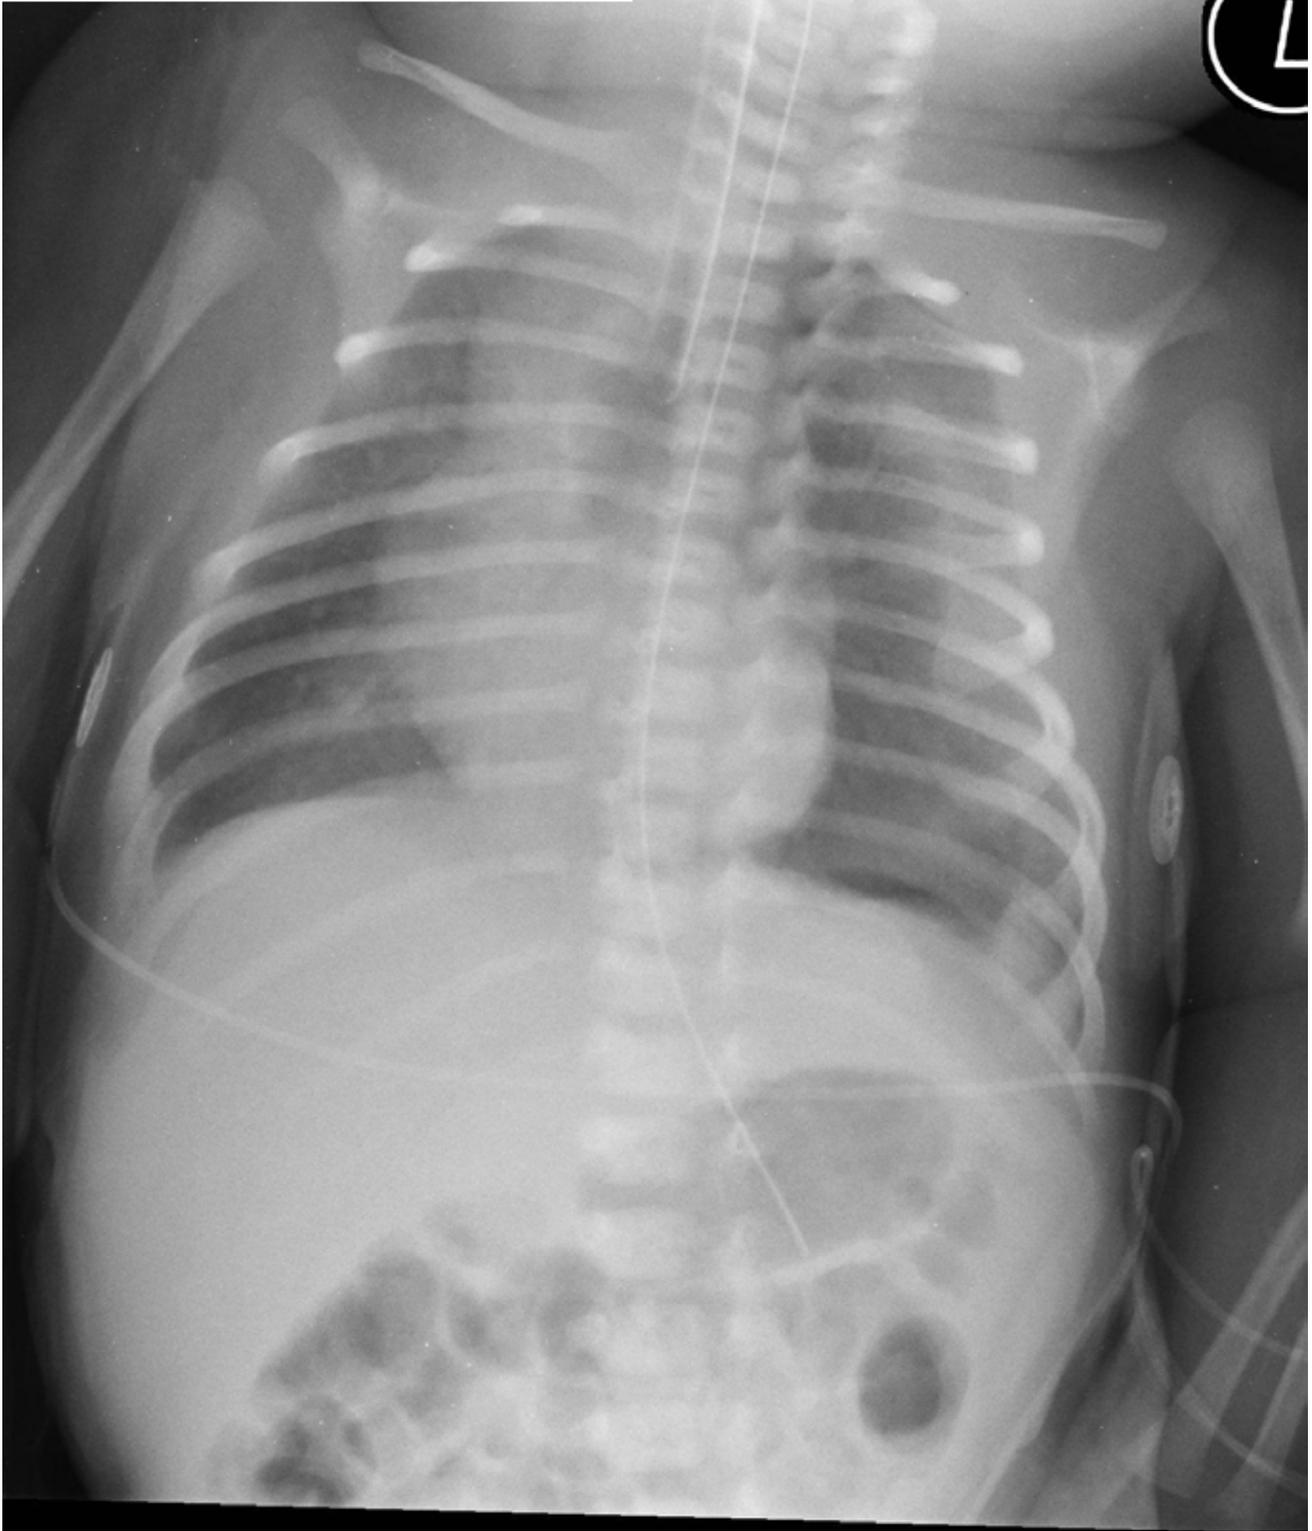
Chest x-ray repeated after 2 hours showing well expanded left lung and no evidence of pneumothorax
